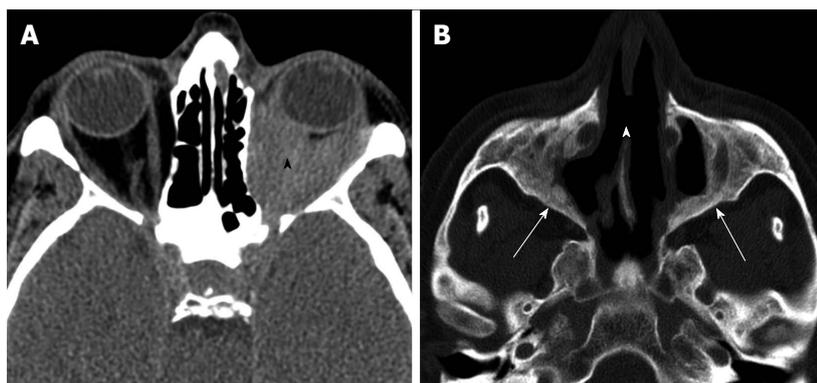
Wegener's granulomatosis. A: Non-enhanced axial CT through orbit demonstrating diffuse infiltration of orbital fat (black arrowhead); B: Axial CT in through sinuses in bone window shows destruction of medial maxillary sinus walls, perforation of nasal septum (white arrowhead), and chronic neo osteogenesis along sinus walls (white arrows). CT: Computed tomography.
